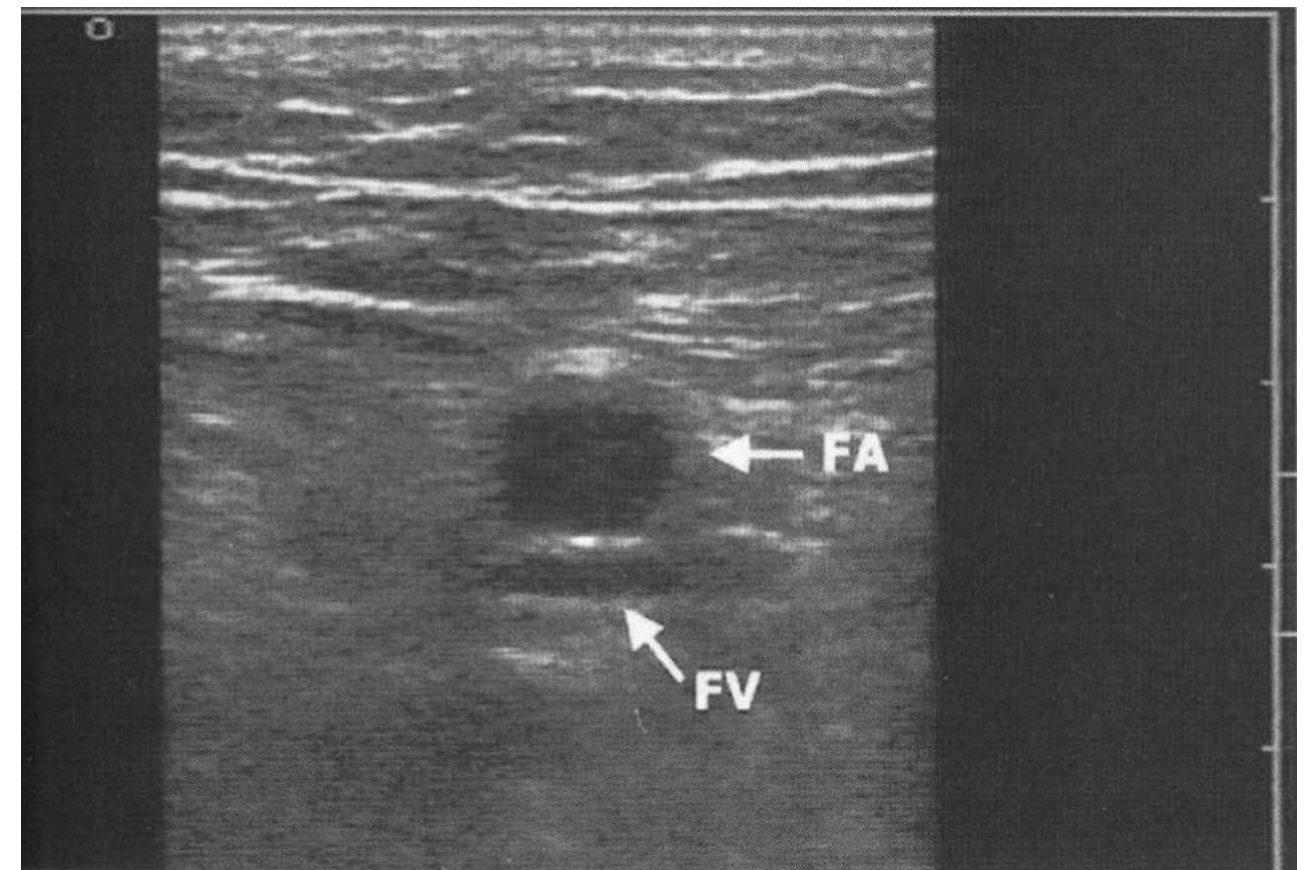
Incomplete collapse of the femoral vein. If adequate pressure has been applied, this view indicates a thrombus is likely present within the femoral vein. FV, femoral vein; FA, femoral artery. (Reproduced with permission from Ma OJ, Mateer, JR, & Blaivas M: *Emergency Ultrasound*, 2nd edition. New York: McGraw-Hill Publishing; 2007.)
